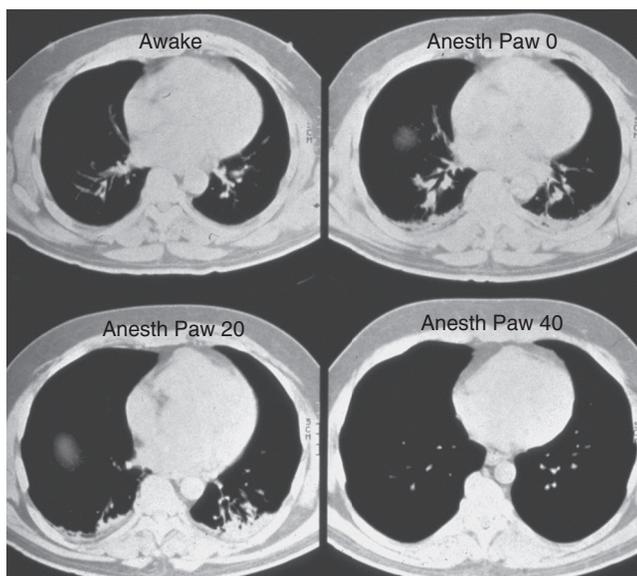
Computed tomographic (CT) scans during awake and anesthetized states with altered airway pressure (P_{AW}). The CT scan in the awake subject (upper left panel) shows normal vasculature and no atelectasis. During anesthesia (P_{AW}, 0 cm H₂O; upper right panel), bilateral basal atelectasis is seen; the PAW is increased in increments (20 cm H₂O shown), but the atelectasis is not reversed until a P_{AW} of 40 cm H₂O is applied (lower right panel). Thus, a vital capacity maneuver was required to open the lung. (From Rothen HU et al: *Re-expansion of atelectasis during general anaesthesia: a computed tomography study*, *Br J Anaesth* 71:788-795, 1993.)
